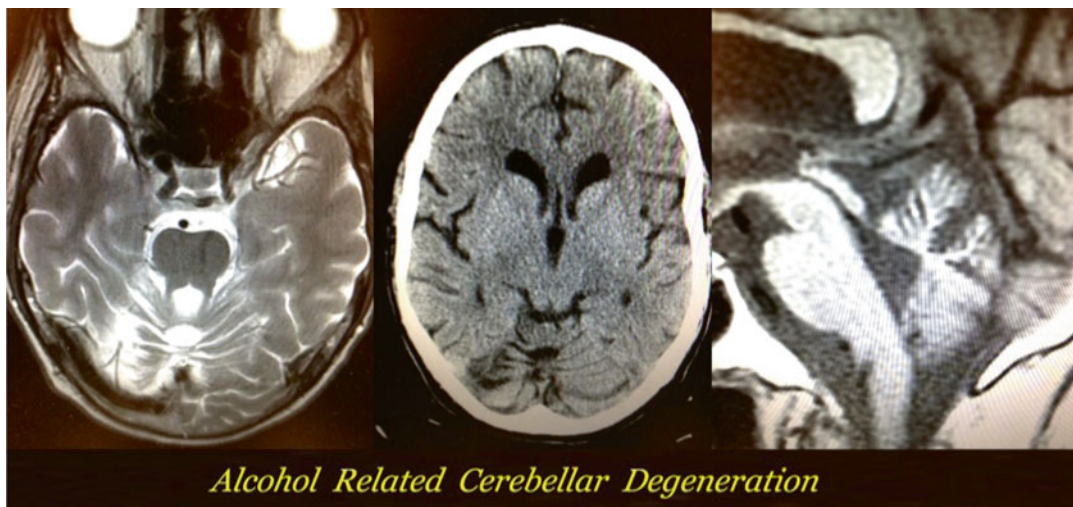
Long-term superior cerebellar vermis atrophy secondary to chronic heavy use of alcohol over many years as shown by CT (center) and MRI (left and right panels)
